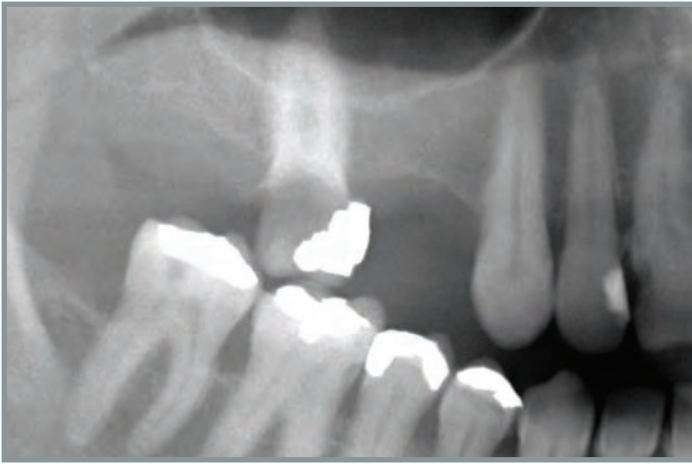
Preoperative radiograph. Note 5-6 mm of bone available under maxillary sinus. Enough bone availability in maxillary tuberosity.
